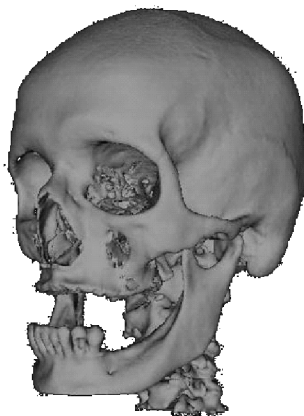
From CT to FE model.
